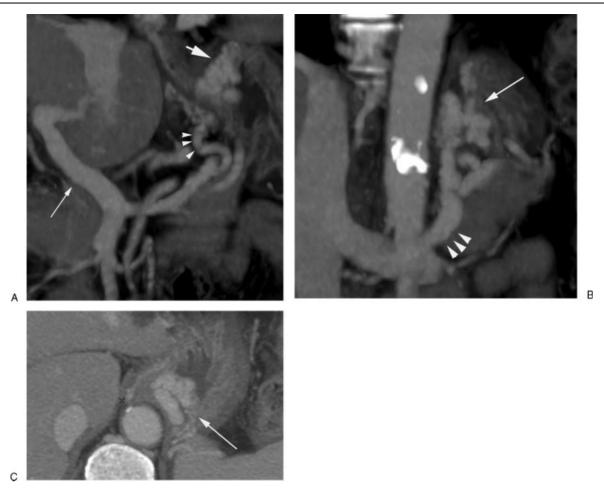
Preprocedural imaging with contrast-enhanced computed tomography (CECT).(A) Oblique coronal CECT shows patency of the main portal vein (small arrow). The posterior gastric vein (arrowhead) is the main feeding "afferent" vein for the gastric varices (large arrow). (B) Oblique coronal CECT shows gastric fundal varices (arrow) and gastrorenal shunt (arrowheads). (C) Axial CECT shows gastric fundal varices (arrow).
